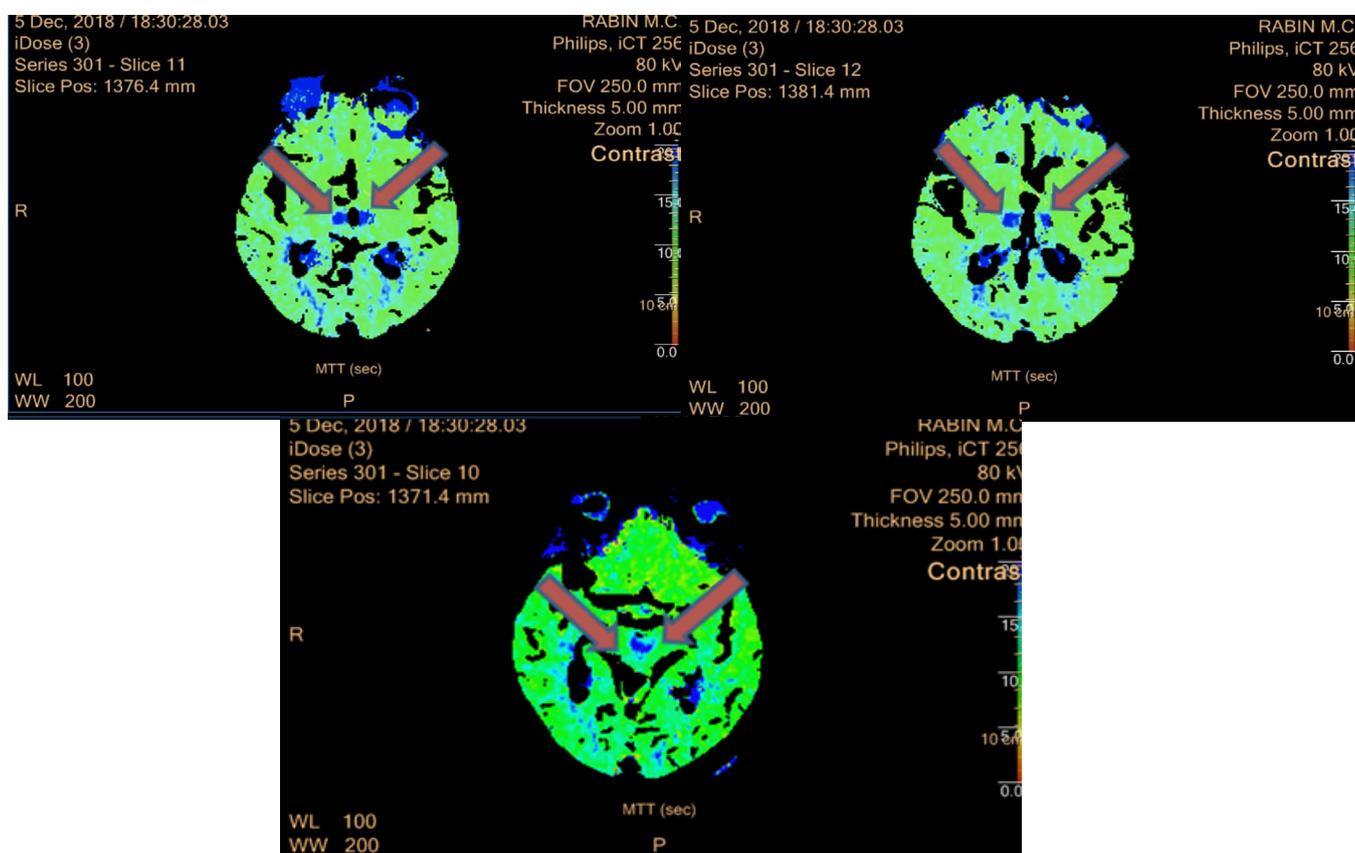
CT Perfusion MTT maps showing high MTT in bilateral medial Thalami and rostral midbrain (arrows), making the diagnosis of AOP stroke.
